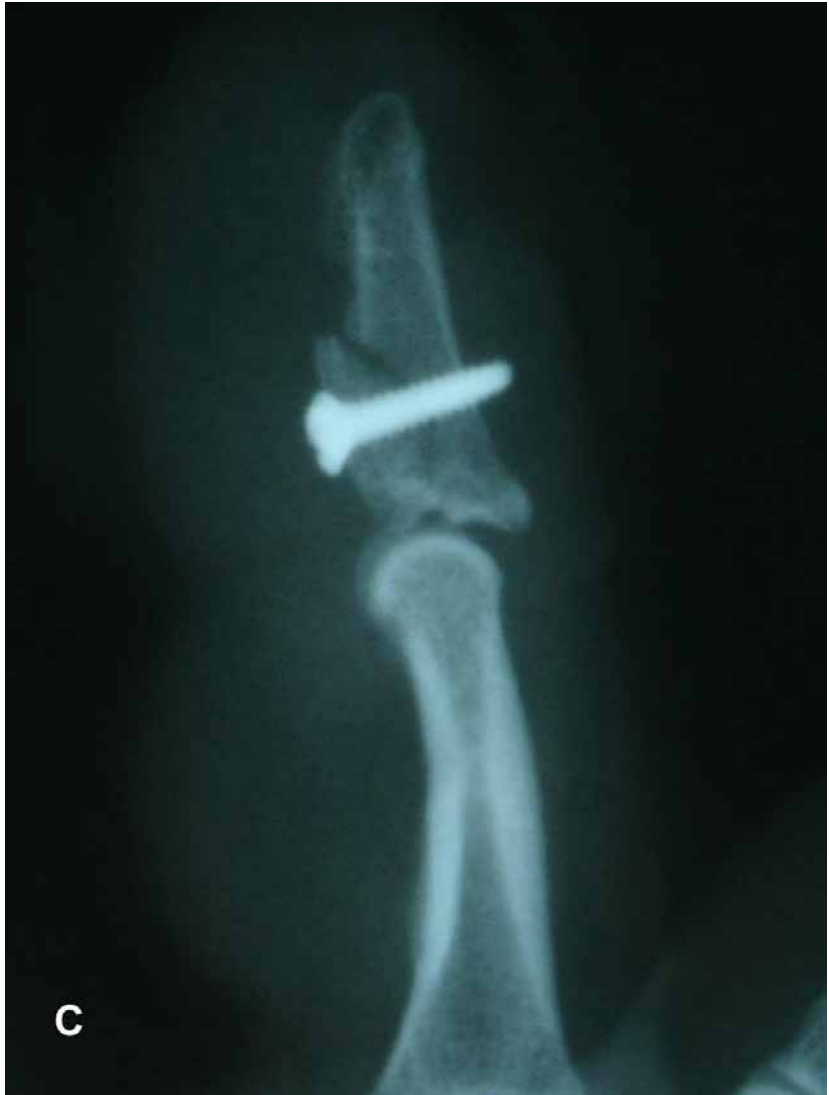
The Leddy Type 3 fracture/FDP avulsion depicted on x-ray in Figure 2-33B. A, The tendon/bone end is just proximal to the retractors and the dark space above is the recipient bed. B, The tendon is reattached (B) and secured (C) with a cortical screw.
